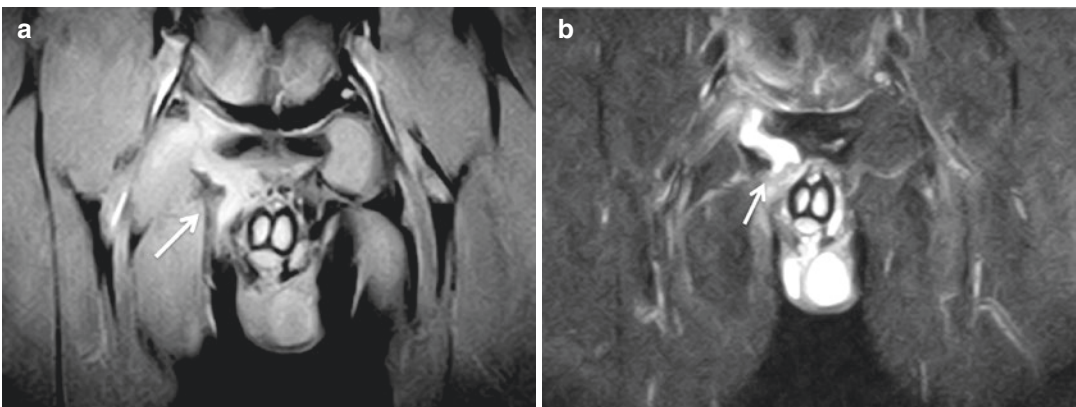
(a) MRI coronal FWGE SAT and (b) MRI coronal STIR demonstrating complete detachment of adductor longus muscle enthesis with hematoma formation
